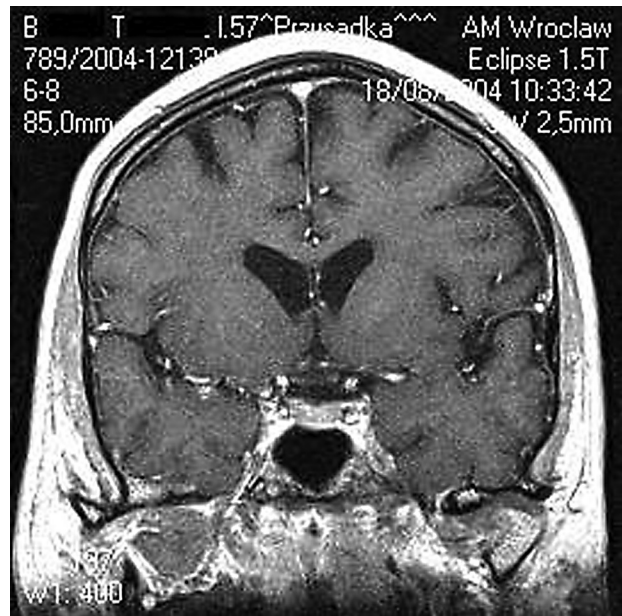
(MR 18.08.2004) Coronal contrast-enhanced T1-weighted MR image shows no pathological changes within the suprasellar region. Optic chiasm is still normal; regression of the lesion
